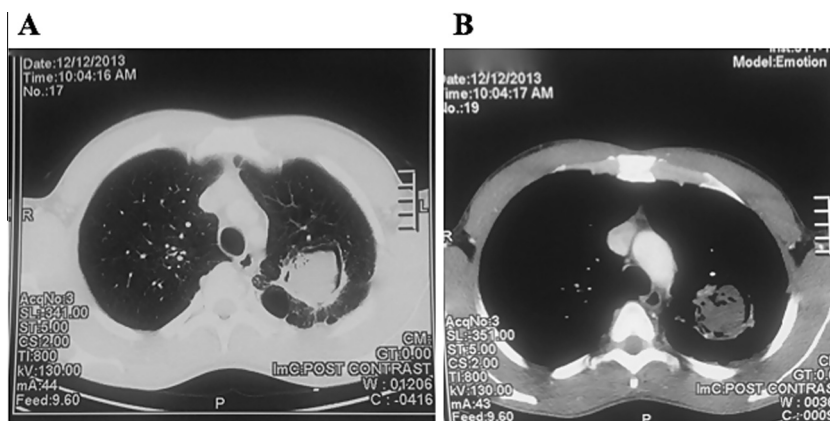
Chest computed tomography scan showing bilateral apical post-tuberculosis lung fibrosis and a left apical 5.5 × 5.4-cm² thick-walled cavity with a solid intracavity mass with air crescent sign. (A) Lung; (B) mediastinal window.
